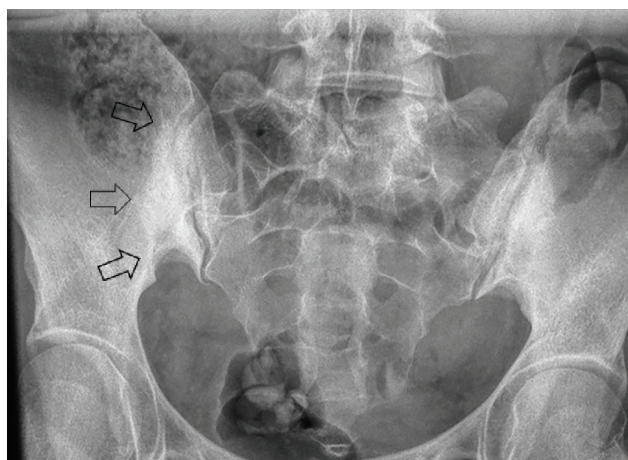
Radiograph of the sacroiliac joints from the patient's evaluation at the rheumatology clinic shows bilateral subchondral sclerosis on the iliac side, consistent with osteitis condensans ilii. The triangular-shaped area of sclerosis, a hallmark radiographic feature of osteitis condensans ilii, is best appreciated on the right side (arrows).
